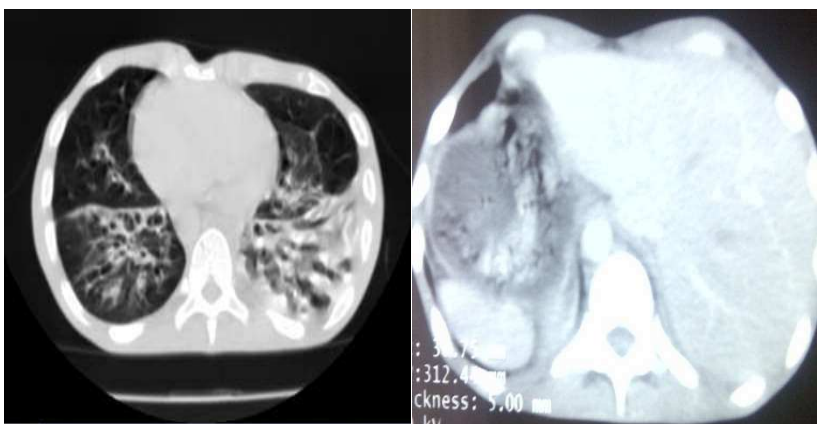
Abdominal chest CT scan showed bronchiectasis and situs inversus
